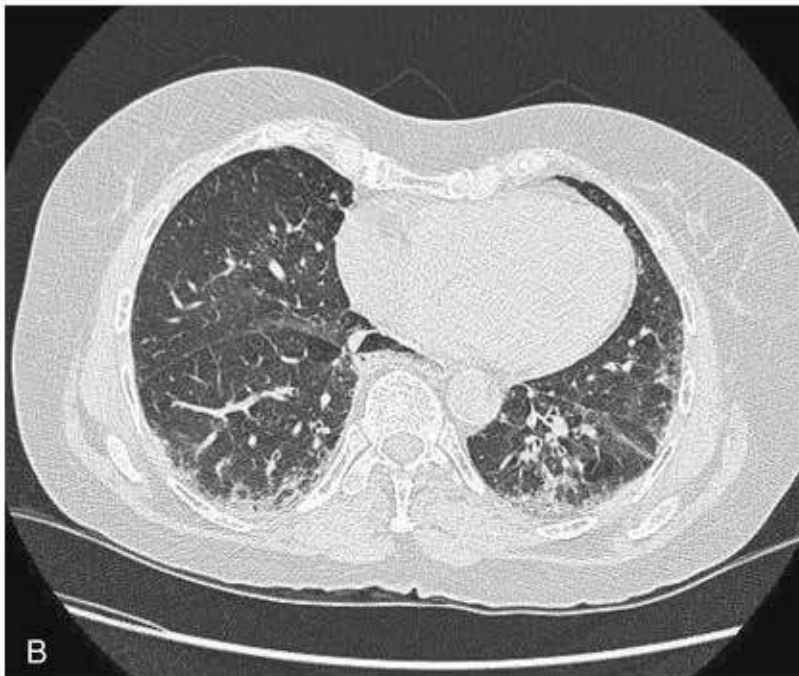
Systemic sclerosis. A, Chest radiograph of a patient with dSSc showing interstitial shadowing, mainly in the lung bases, along with associated loss of volume, consistent with early pulmonary fibrosis. B, CT of the thorax demonstrating ground-glass opacity, subpleural honeycombing
